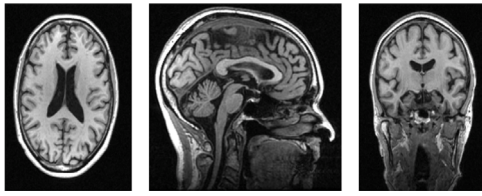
The three views of a 3D MRI image. These views are axial view, sagittal view, and coronal view. Various views can depict different structural information of the brain.
